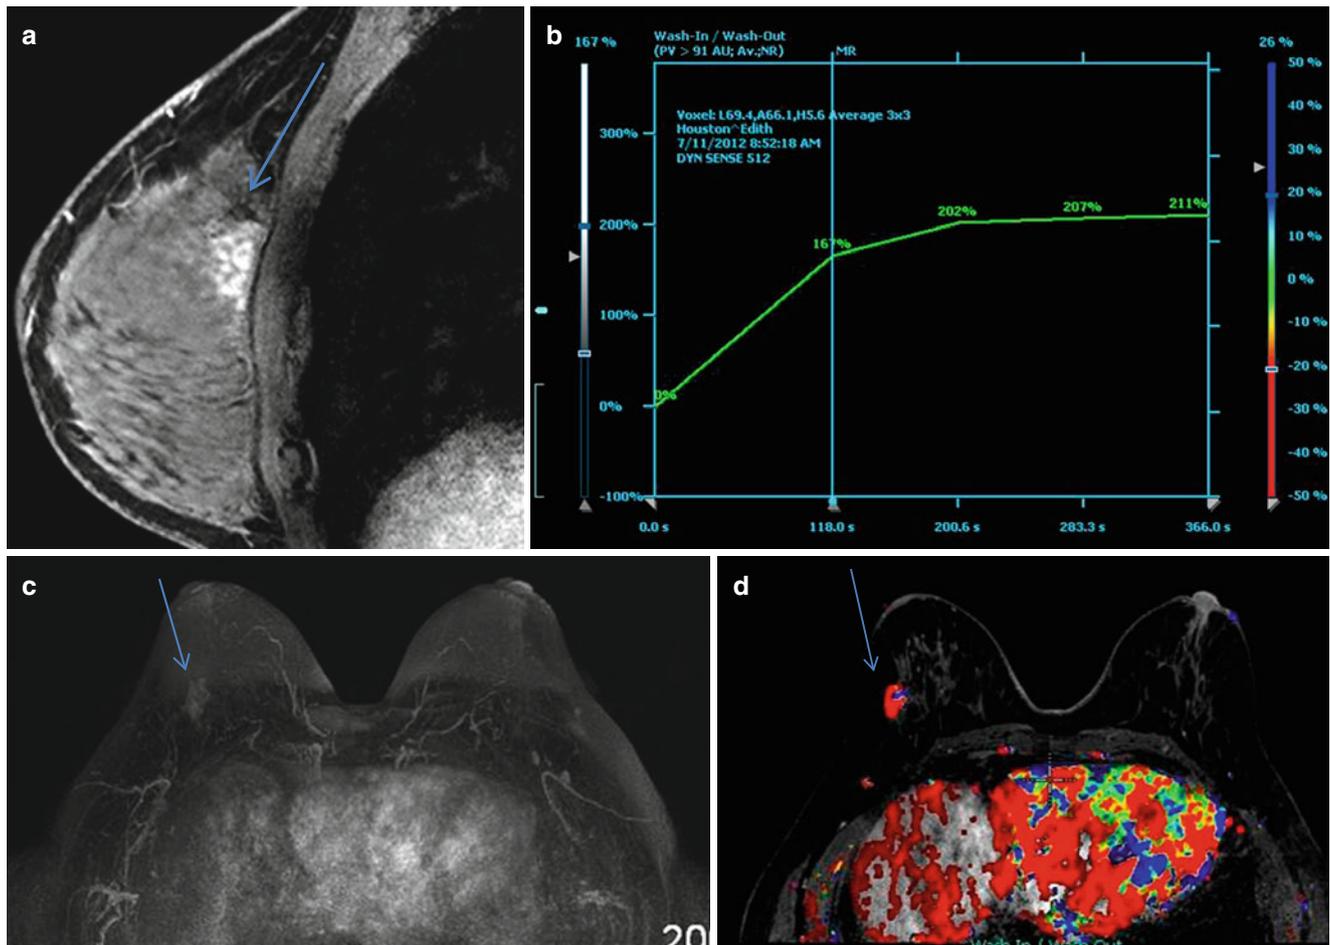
(a–d) Non-mass-like enhancement [NMLE]. (a) Sagittal postcontrast T1-weighted image shows a segmental area of non-mass-like enhancement in the posterior upper right breast. (b) Kinetic curve demonstrates slow uptake and progressive enhancement characteristic
